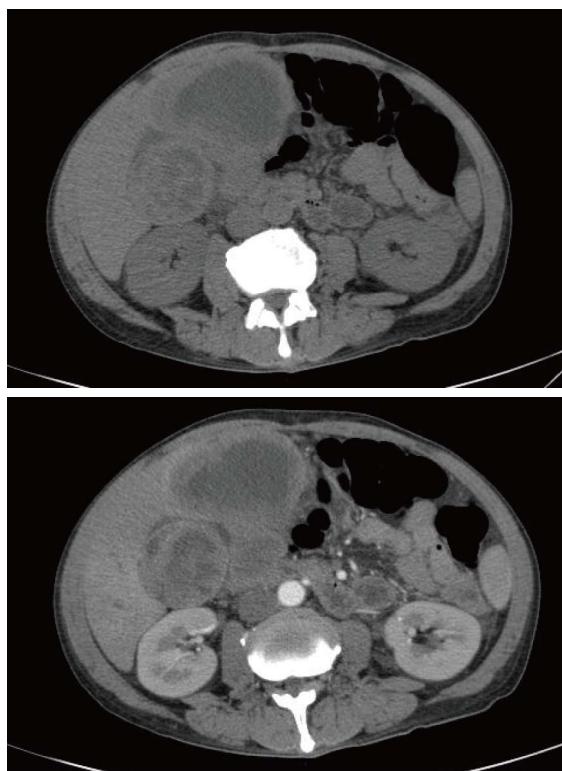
Computed tomography scan (simple and arterial phase) with infiltrative lesion at duodenum and gallbladder.
